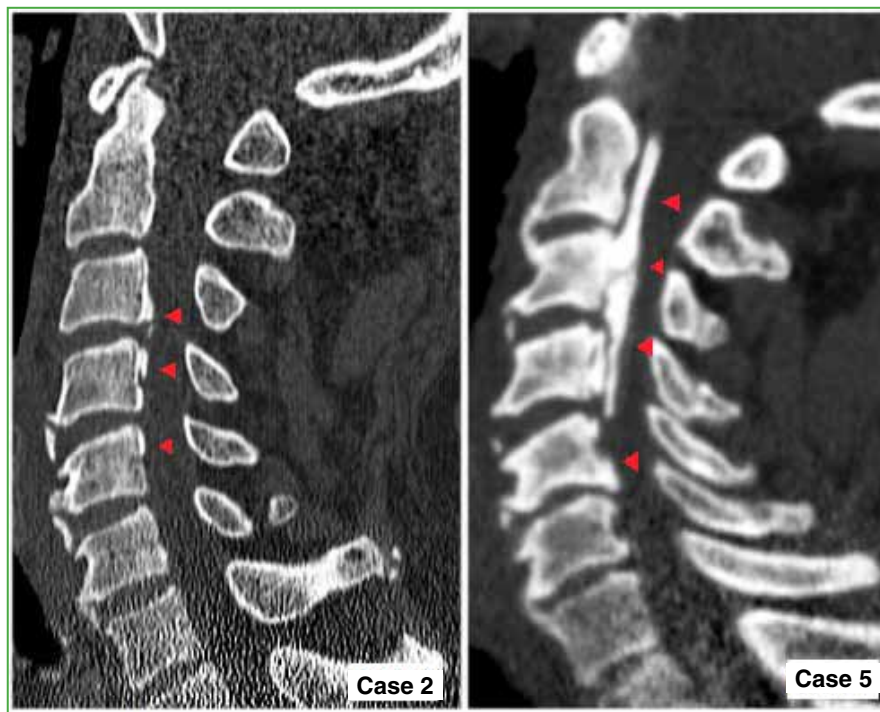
Computed tomography, sagittal plane. Characteristic images of ossification of the posterior longitudinal ligament (arrows), segmental (Case 2) and mixed (Case 5) are observed.
